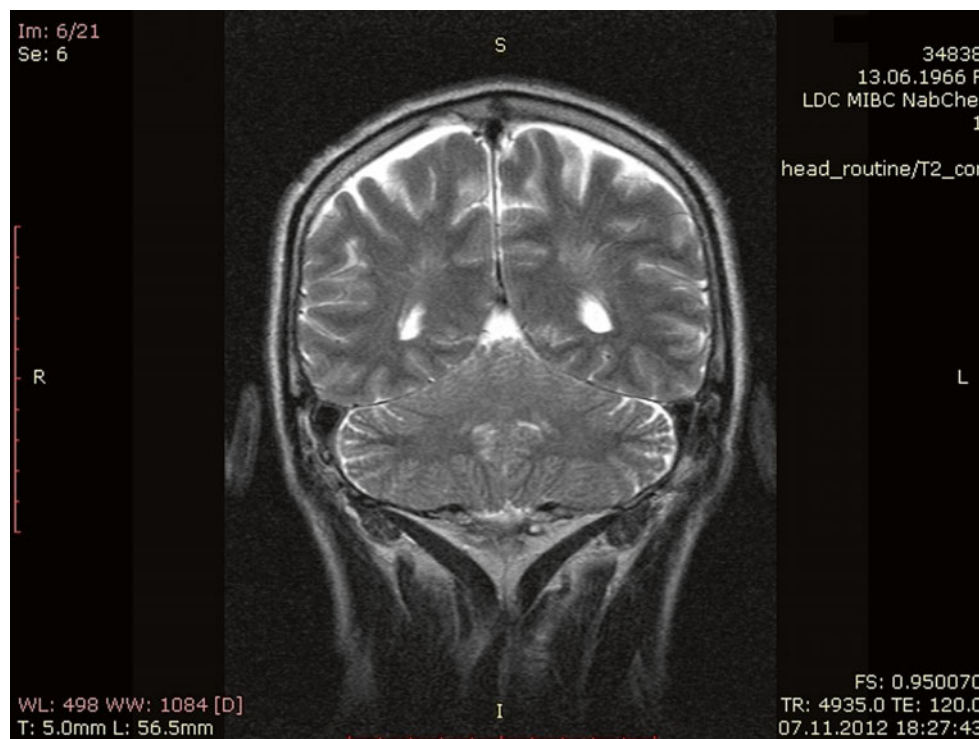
Coronal T2-weighted MRI in a 46-year-old male patient, with cerebral atherosclerosis and specific ependymal-WM-high-intensity signal (HIS) architectonic around the peri-trigonal region. Magnification $\times 400$
